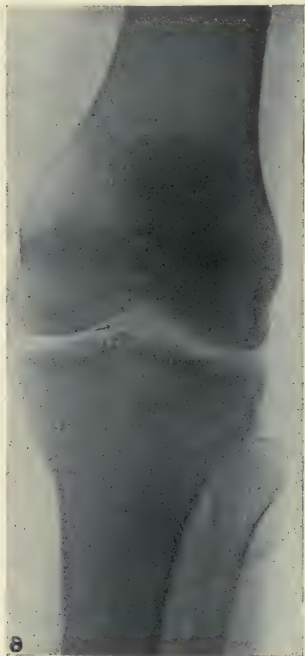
Fracture of tibial spine. Fragments indicated by arrow. This accident detaches the crucial ligaments from their moorings and relaxes the knee-joint. The tibia can be passively moved to and fro (antero-posteriorly) on the femur when the knee is flexed—a clinical feature of great diagnostic value. The diagnosis was confirmed by radiograph in this case.
